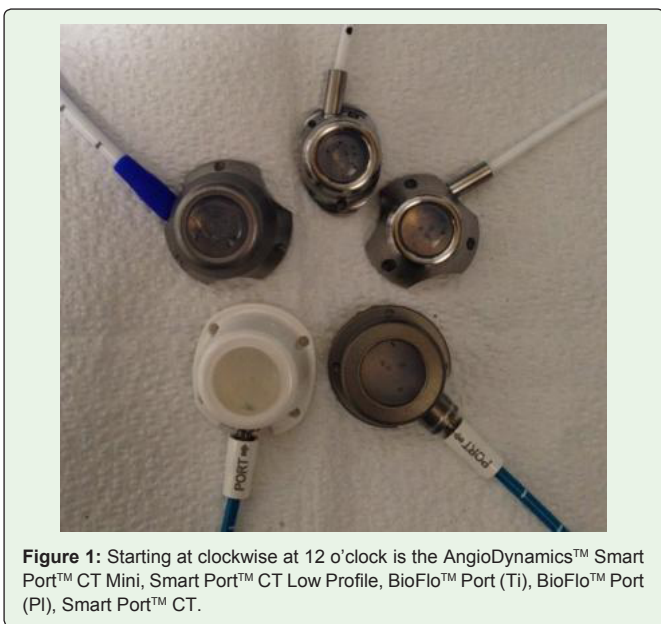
Starting at clockwise at 12 o'clock is the AngioDynamics™ Smart Port™ CT Mini, Smart Port™ CT Low Profile, BioFlo™ Port (Ti), BioFlo™ Port (PI), Smart Port™ CT.
